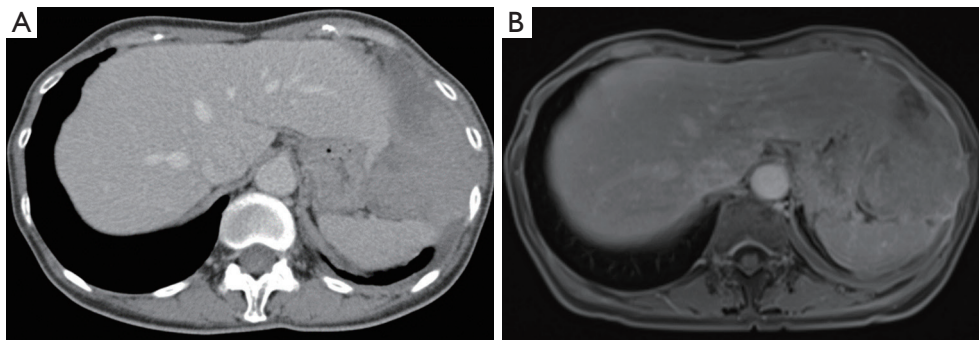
Comparison of contrast-enhanced computed tomography and T1-weighted magnetic resonance imaging in respect to soft tissue resolution and identification of chest wall infiltration. (A) Axial view of the left-sided MPM on contrast enhanced computed tomography of the chest; (B) T1-weighted magnetic resonance imaging with better soft tissue contrast and therefore providing more details on chest wall and diaphragm invasion.
